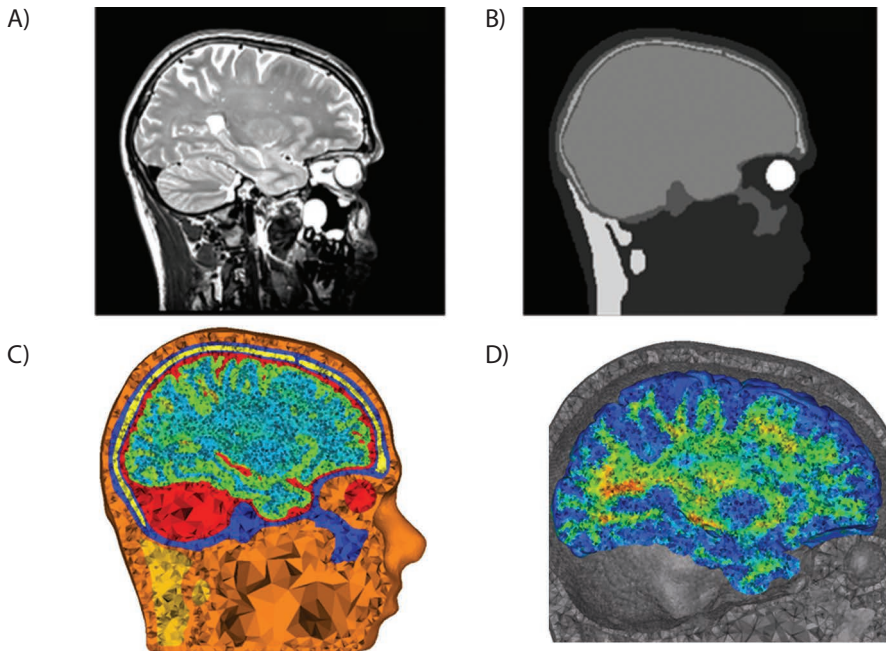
(A) A sagittal cut plane of the T2w MRI showing the different skull layers. (B) The same sagittal cut plane of the manually corrected segmentation including skin, skull compacta, skull spongiosa, neck muscle, eyes and one compartment for inner skull (CSF, GM and WM, before segmentation with Free-surfer). (C) Sagittal cut plane of the final tetrahedral volume mesh. The different tissue types are represented with different colors. The corresponding bulk conductivities are given in table 7.1. (D) Sagittal cut plane of the brain mesh with the fractional anisotropy on a scale from 0 (blue) to 1 (red). The maximal fractional anisotropy value in the brain is 0.99 and the minimum is 0.
